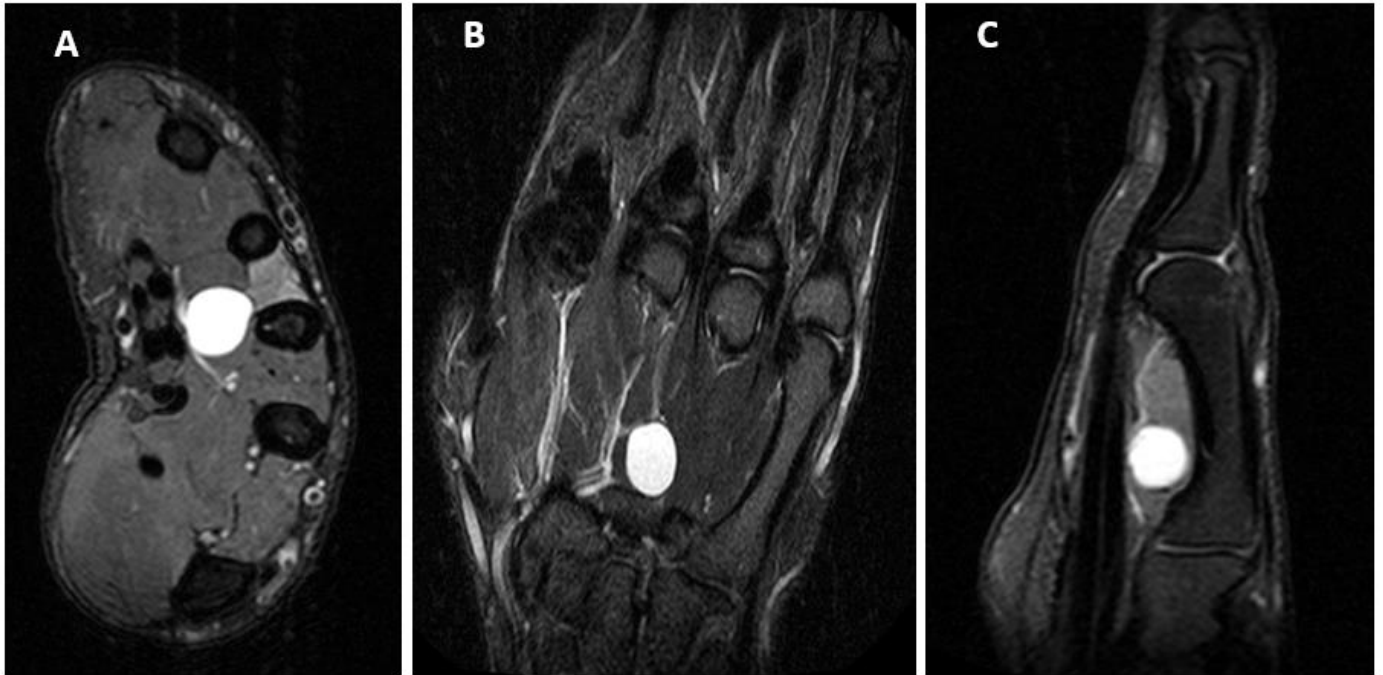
Right hand magnetic resonance imaging (MRI), including (A) axial, (B) coronal, and (C) sagittal T2-weight images, demonstrating T2-hyperintense 1.1cm x 1.2cm x 1.4cm mass between the third metacarpal and flexor digitorum profundus tendon. Also noted, increased T2-hyperintense signal within the third dorsal interosseous muscle, and to a lesser degree, in the flexor pollicis brevis muscle
